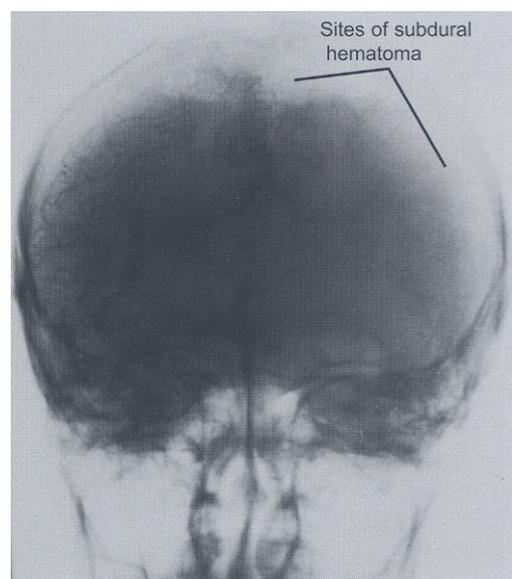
Radiographic image of the skull showing the extent of subdural hematoma
